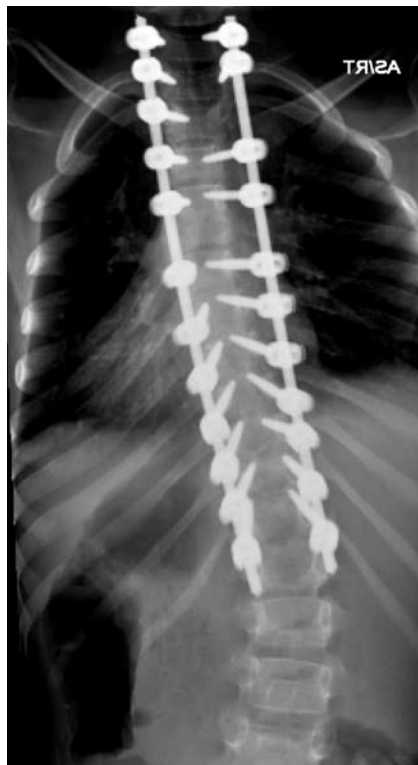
AP digital radiograph demonstrates significant correction of the coronal thoracic deformity.
